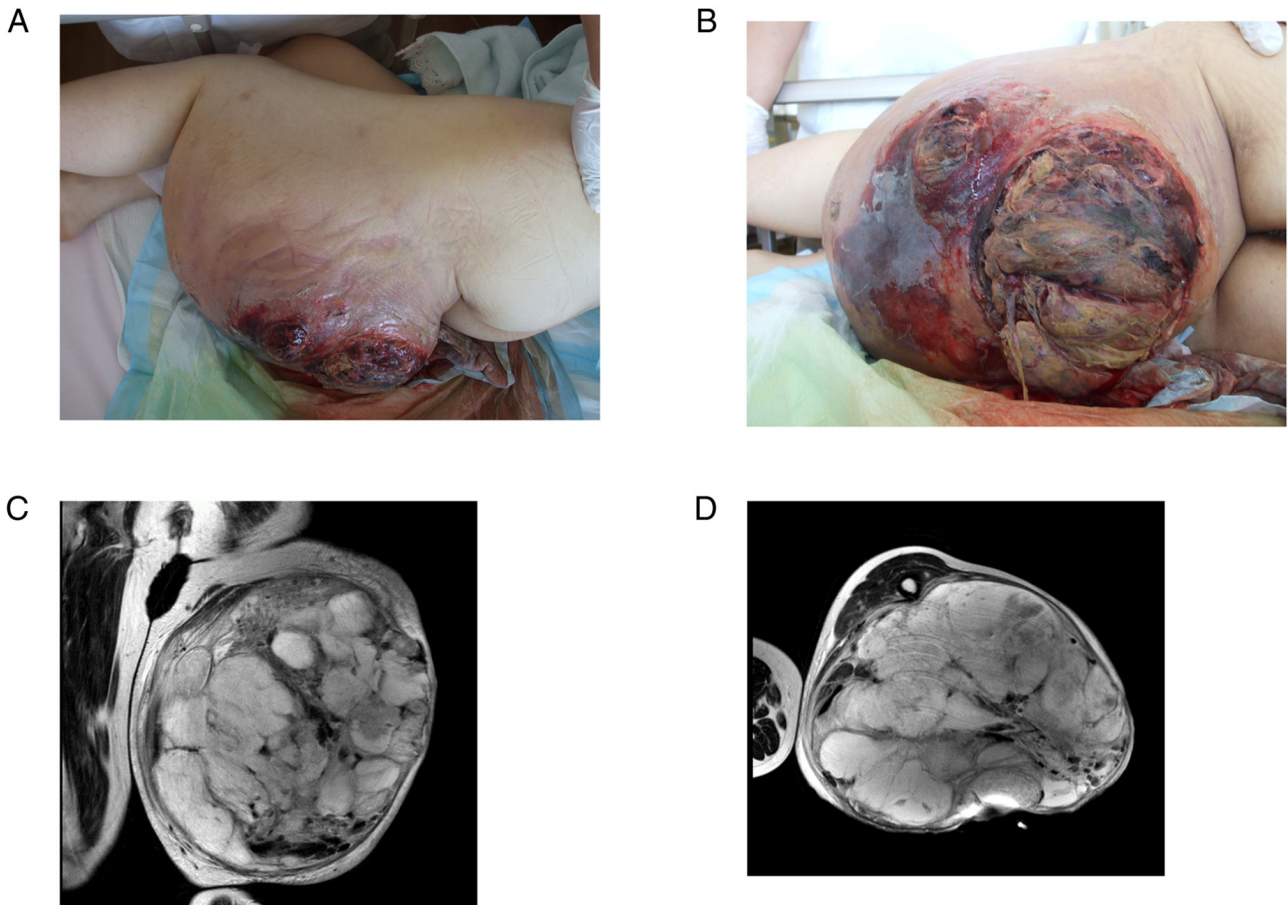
A patient with sepsis. A 42-year-old woman with sepsis from the malignant wound of myxoid liposarcoma in the thigh. (A and B) The skin overlying the large tumor in the left thigh was bleeding and had a foul odor and exudate. (C and D) MRI revealed a mass with high intensity on T2-weighted images.
